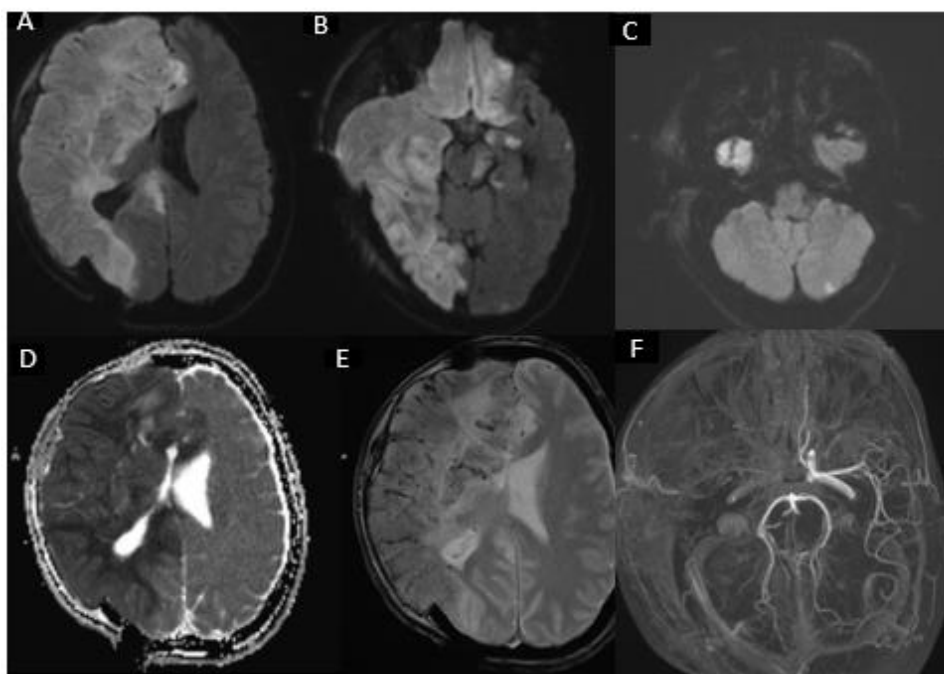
Brain MRI images (A–C) in axial diffusion-weighted sequences demonstrate a right hemispheric hyperintense signal consistent with an acute ischemic process, exerting a compressive effect and extending to involve the left fronto-temporo-occipital region, as well as the left mesencephalic and cerebellar areas, with corresponding ADC restriction (D). Image (E), an axial T2-weighted echo sequence, reveals areas of hemorrhagic transformation within the infarcted regions. Image (F), a time-of-flight magnetic resonance angiography (TOF-MRA), shows an abrupt cutoff of the right internal carotid artery (ICA) with non-visualization of its distal branches, consistent with arterial occlusion secondary to dissection.
